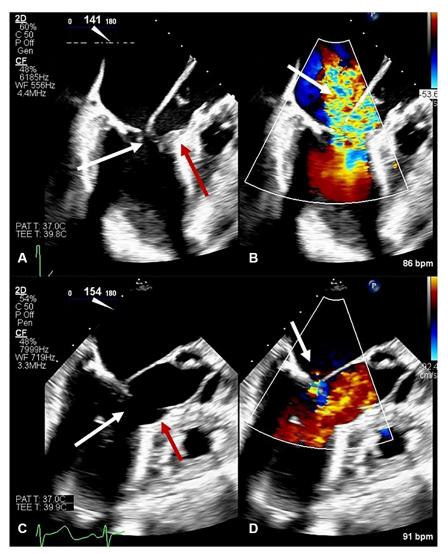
Intraoperative transesophageal echocardiography before and after septal myectomy. A, Systolic anterior motion of the mitral leaflets (*white arrow*) and subaortic septal hypertrophy (*red arrow*). B, The white arrow points to the Doppler signal of severe mitral valve regurgitation. C, Following septal myectomy the left ventricular outflow tract is widely patent (*white arrow*), and the myectomy site is easily visible (*red arrow*). D, Only trivial residual mitral regurgitation (*white arrow*).
